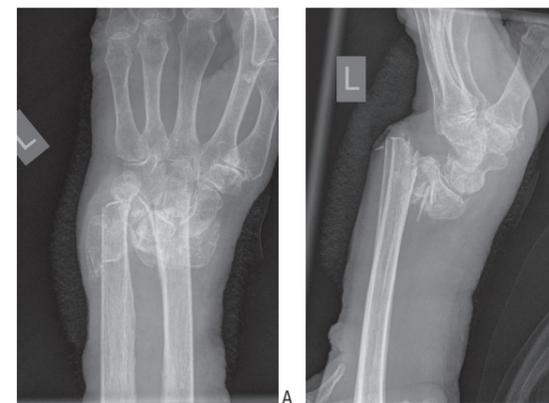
An X-ray of the fracture at follow-up assessment at 2.5 years: A. p-a view; B. lateral view. Note palmar displacement of the distal radius (angulation of 60°), and palmar shift of the carpus of about 1.5 cm
